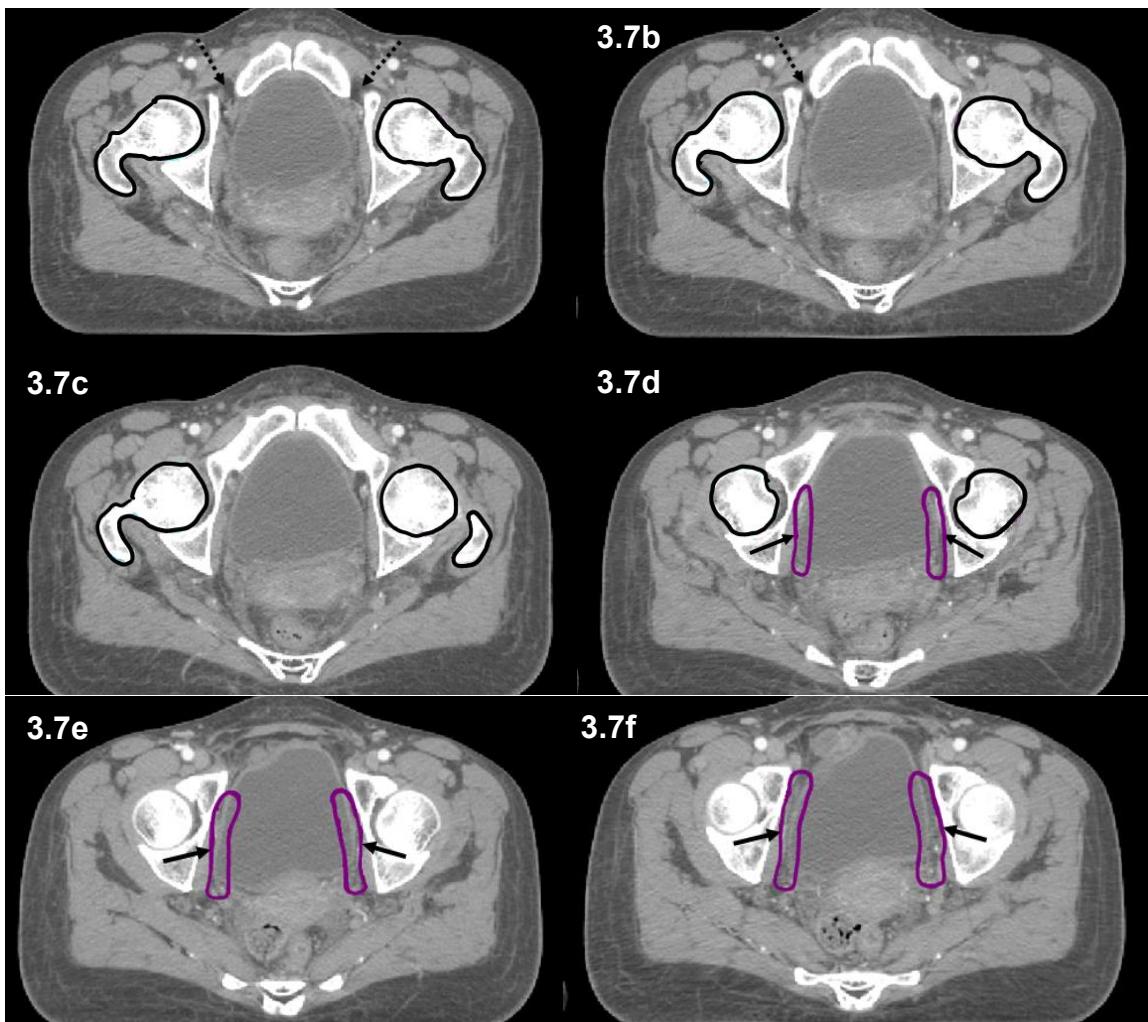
Axial CT of inferior extent of CTV2 (purple) ~ mid-axial slice of femoral heads (black) and ~1cm superior from the top of obturator foramen (dashed arrows)
